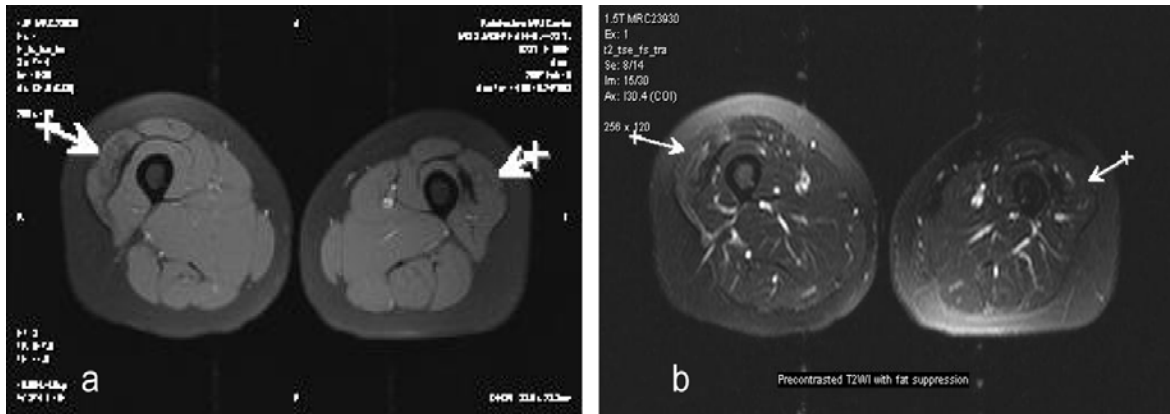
Axial MRI of the thighs showing the T1-weighted (a) and the T2-weighted (b) image with fatty atrophy of the vastus lateralis muscles associated with fibrous structure anterolaterally
